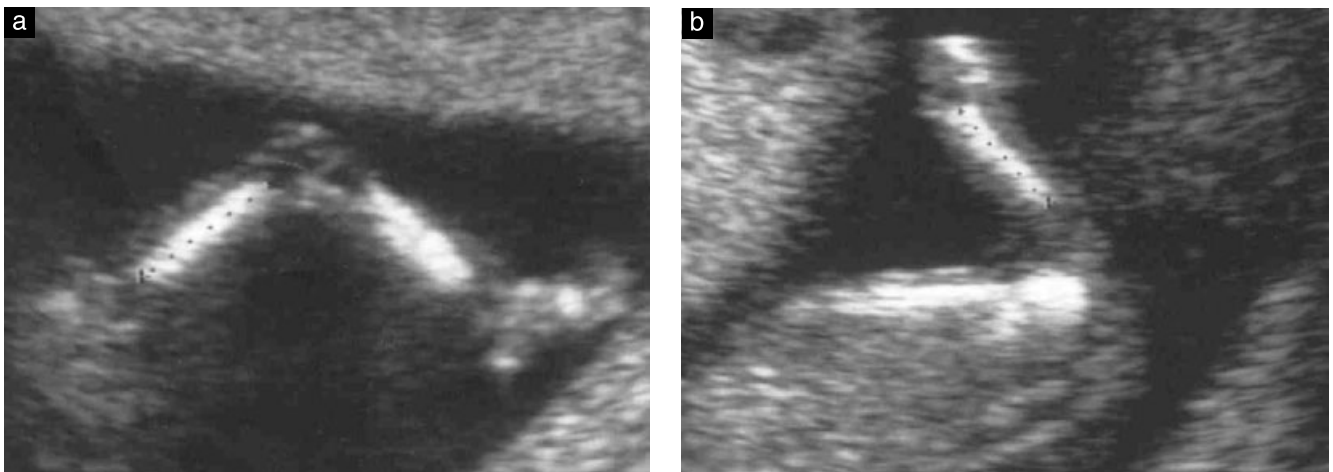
Ultrasound image of a 12-week fetus demonstrating measurement of (a) femur and (b) humerus length.
